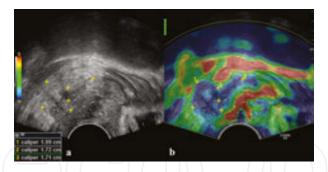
Rectal tumor. Gray scale ultrasound (a) and sonoelastographic examination (b). To be noticed the perirectal fat invasion.
